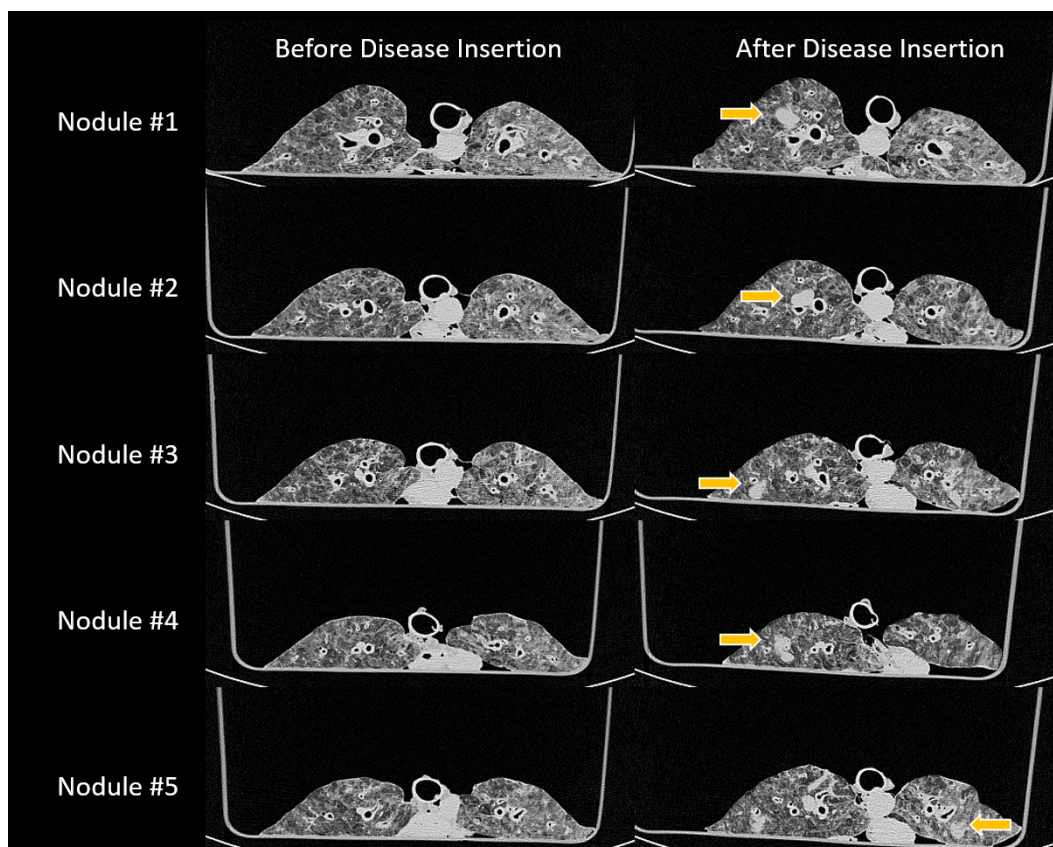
CT images of the *ex-vivo* lungs before and after disease model insertion. All five of the inserted lung nodules were successfully formed, with four in the right lung and one in the left lung. The mean HU values for the five nodules were $-9 \text{ HU} \pm 18 \text{ HU}$, $24 \text{ HU} \pm 48$, $-19 \text{ HU} \pm 23$, $-18 \text{ HU} \pm 49 \text{ HU}$, and $-14 \text{ HU} \pm 8$.
